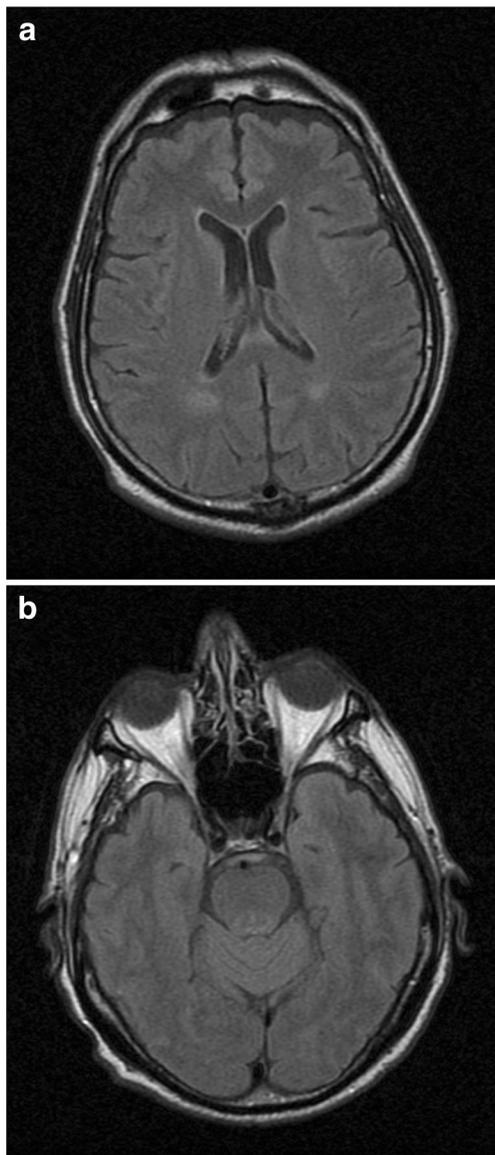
Axial FLAIR slices of the repeat brain MRI showing resolution of prior findings
